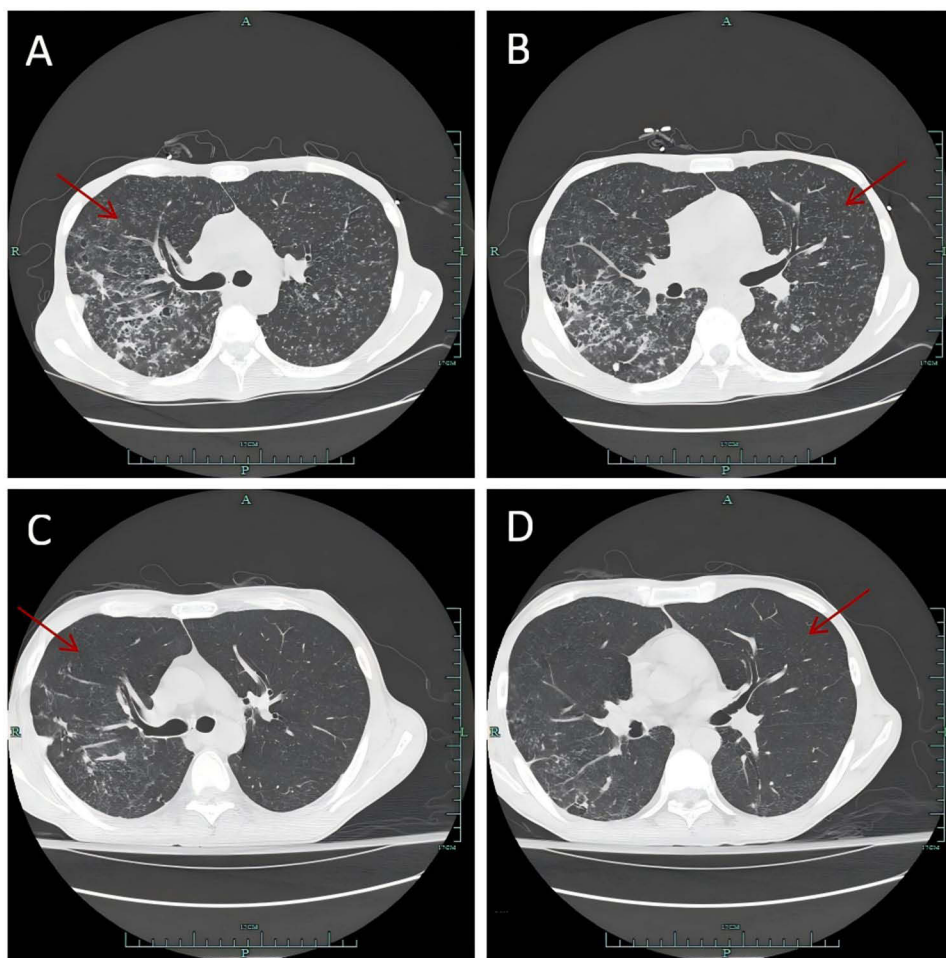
Changes in the lung CT images of the patient before treatment (A and B) and 3 months after treatment (C and D). (A and B) Diffuse miliary shadows in both lungs, with some confluent patchy opacities, more prominent in the right lung. (C and D) The diffuse miliary shadows in both lungs showed significant resolution compared to the previous imaging.
